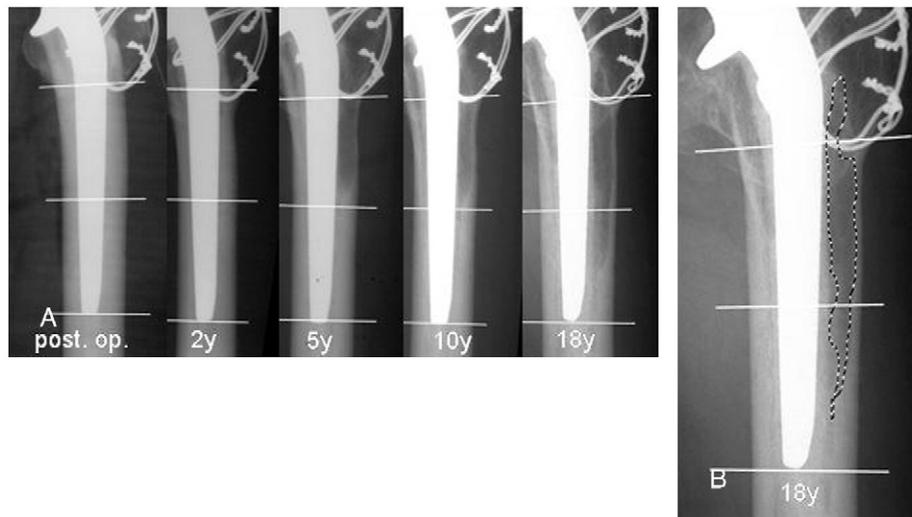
Radiologic evaluation of osteolytic lesions using plain radiographs. Clinical course of the area of osteolysis (A). Area of osteolysis was determined from the edge of the osteolytic area using analysis software. Area surrounded by the dotted line is the measured area of osteolysis (B).
